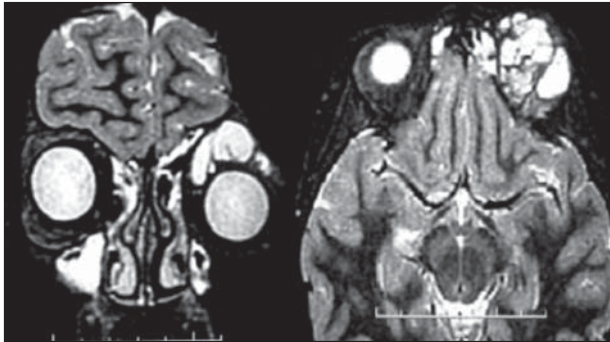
Coronal e axial T2 sequence of pre-operative MRI revealing expansive left orbital lesion, suggesting cavernoma.
